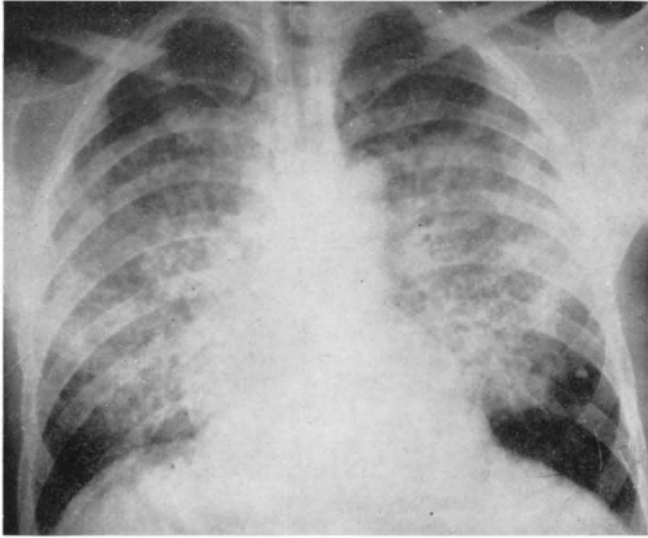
and 3 reveal changes in the chest X-rays on the first day, which had practically disappeared on renewed X-ray examination two days later. During this time the patient's body weight was reduced from 67·3 to 62·8 kg. through loss of fluid. The concentration of N.P.N. in the blood had increased from 131 to 157 mg. per cent between the two examinations.
